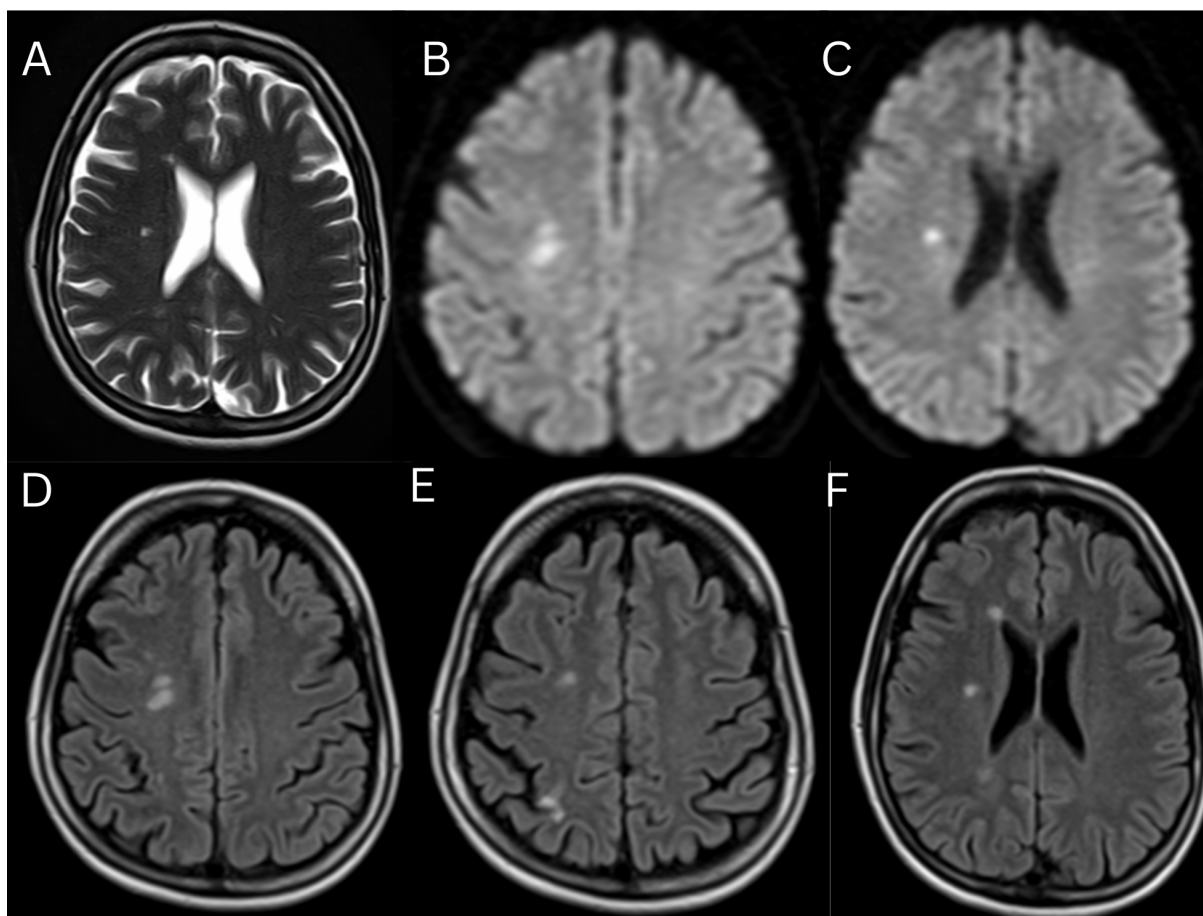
MRI Brain Axial Images T2WI , DWI & FLAIR T2 showing multiple hits in deep white matter in right Centrum semiovale ,periventricular areas and right parietal lobe suggesting watershed infarcts (A,B,C,D,E,F).
